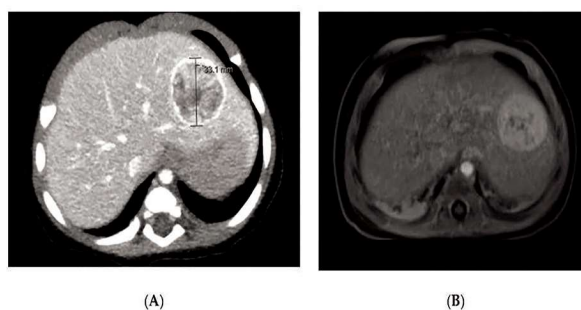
Showing CT/MRI image showing enhanced localised tumor seen within liver
